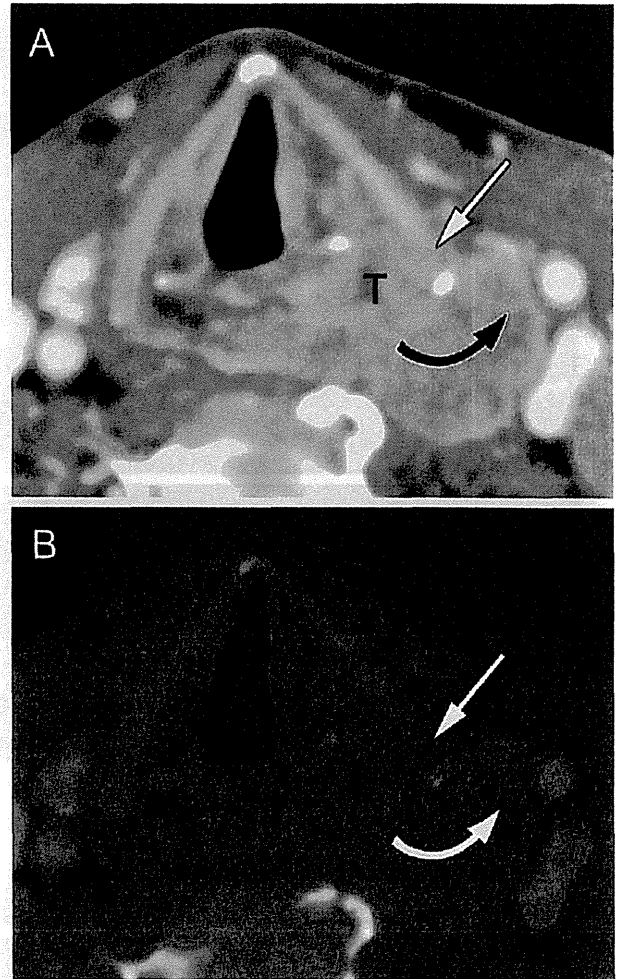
Extralaryngeal spread via the inferior pharyngeal constrictor muscle on dual-energy CT in a 60-year-old man with hypopharyngeal cancer. WA image (A) and IO image (B) at the glottic level show a tumor mass (T) arising from the left piriform sinus, spreading into the lateral extralaryngeal soft tissue via the attachment of the inferior pharyngeal constrictor muscle (curved arrow). The tumor also wraps around the posterior border of the thyroid cartilage. On the WA image (A), the inner cortex of the left thyroid cartilage shows focal lysis (arrow). However, the IO image (B) shows no corresponding enhancement in the region indicated in the WA image (arrow). This case was evaluated as T4a disease without cartilage invasion and treated by chemoradiotherapy.
